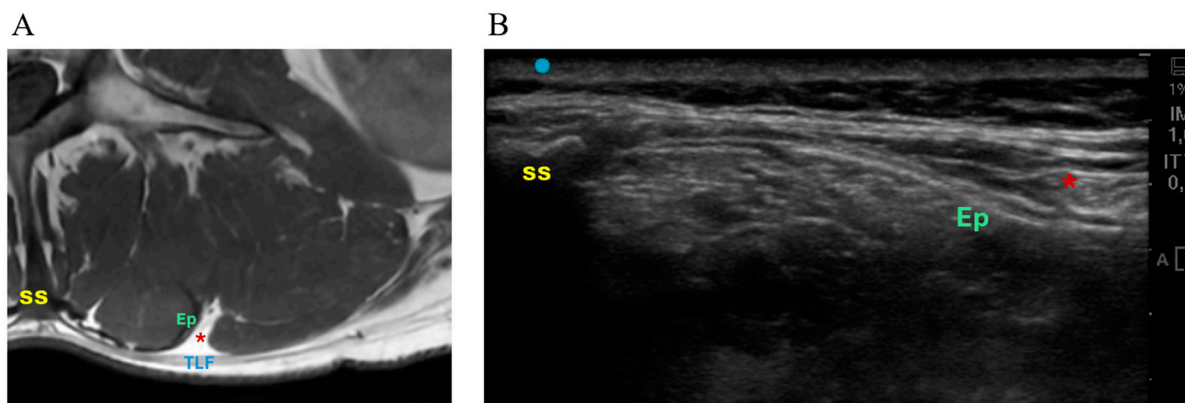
MRI (A) and US (B) at the L3 level of a male subject. SS = spinous process; Ep = epimysium of the erector spinae. On MRI, a triangle-shaped infiltration between the thoracolumbar fascia (TLF) and the epimysium (*) is visible, which may have been interpreted as part of the TLF on the US image.
